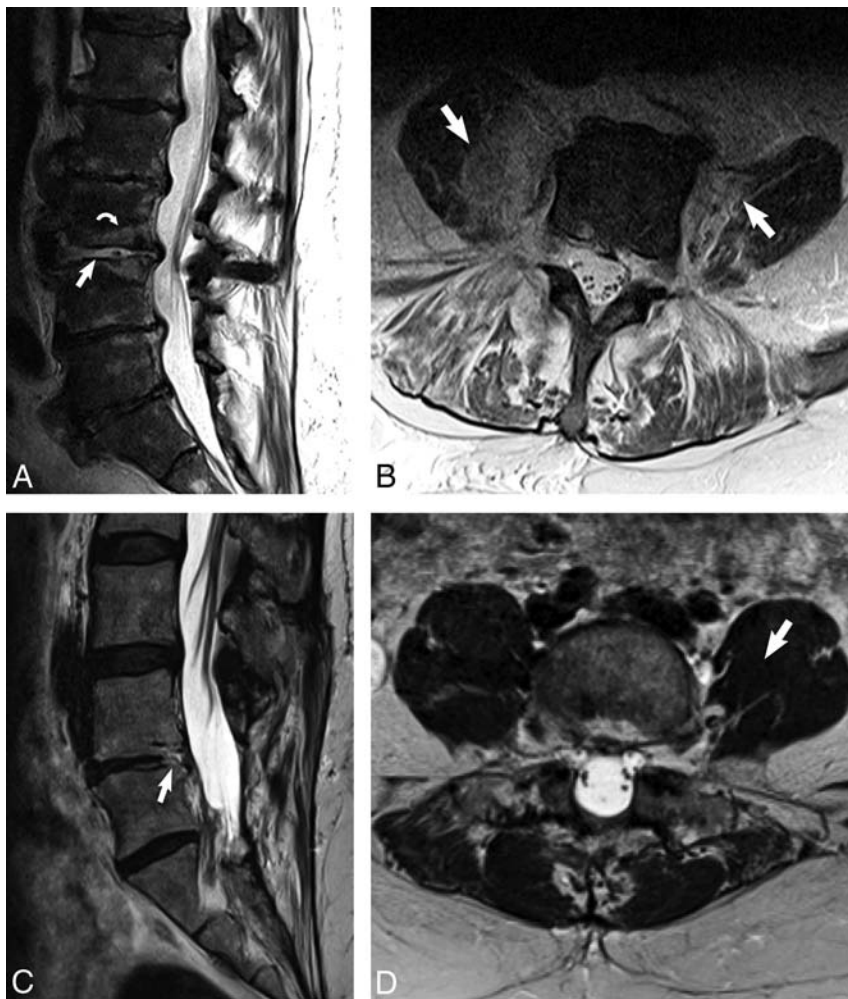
The imaging psoas sign on noncontrast MR imaging of the lumbar spine in an 81-year-old man with renal failure, *E faecalis* bacteremia, and clinically diagnosed discitis-osteomyelitis (A and B) with comparison with degenerative disc disease (C and D). A, Sagittal T2 image demonstrates high T2 signal within the disc (white arrow) and the adjacent endplates (white curved arrow) in the patient with discitis-osteomyelitis. B, Axial T2 image at the level of L3–L4 of the same patient demonstrates the imaging psoas sign of T2 hyperintensity within the bilateral psoas musculature (white arrows). C, Sagittal T2 image in a patient with degenerative disc disease shows focal high T2 signal involving the posterior endplate and disc of L4–L5 (white arrow). D, Axial T2 image in the same patient at the level of L4–L5 shows normal and uniform T2 signal within the psoas muscles (white arrow).
